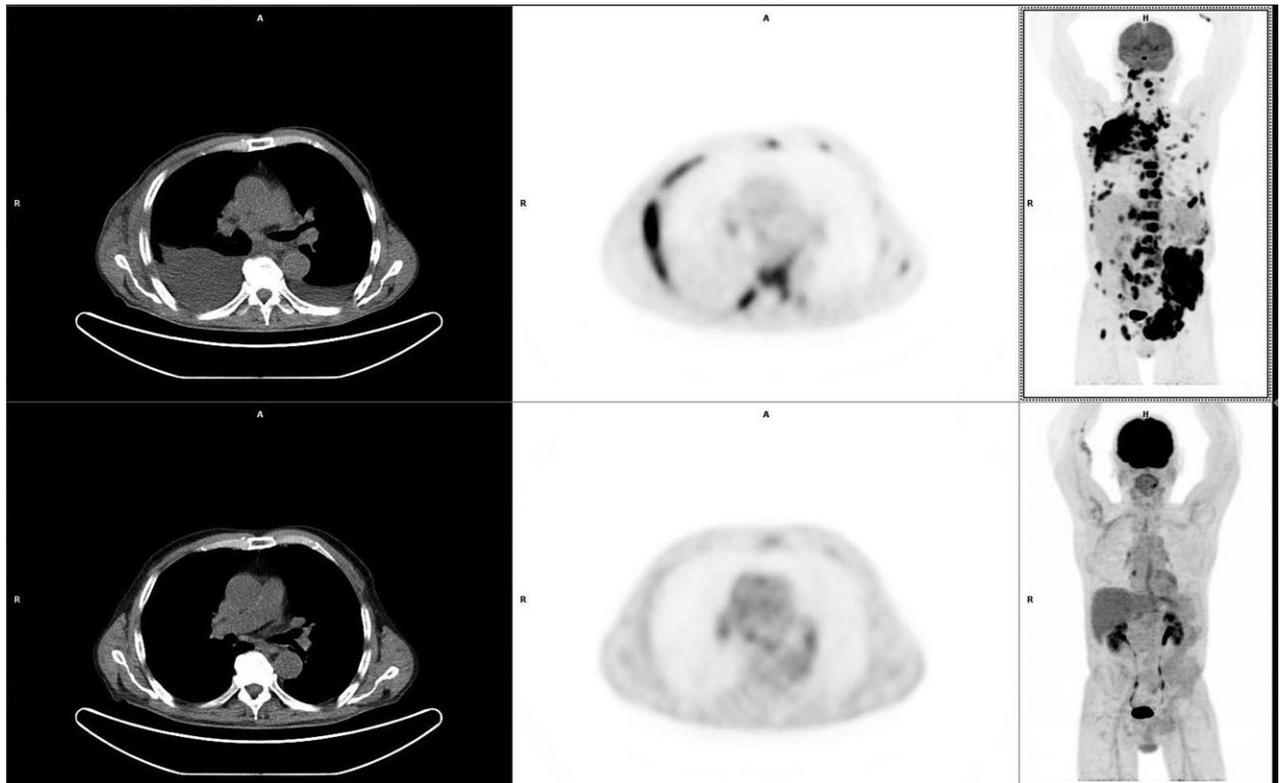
Top and bottom panel rows show computed tomography, transaxial 18-Fluoro-deoxyglucose (FDG) positron emission tomography and maximum intensity projection images of a patient with diffuse large B-cell lymphoma. Top row shows right pleural effusion and extensive FDG-avid lesions at time of diagnosis. Bottom row shows the response after 2 months of chemotherapy. The pleural effusion resolved completely without any pleural intervention.
